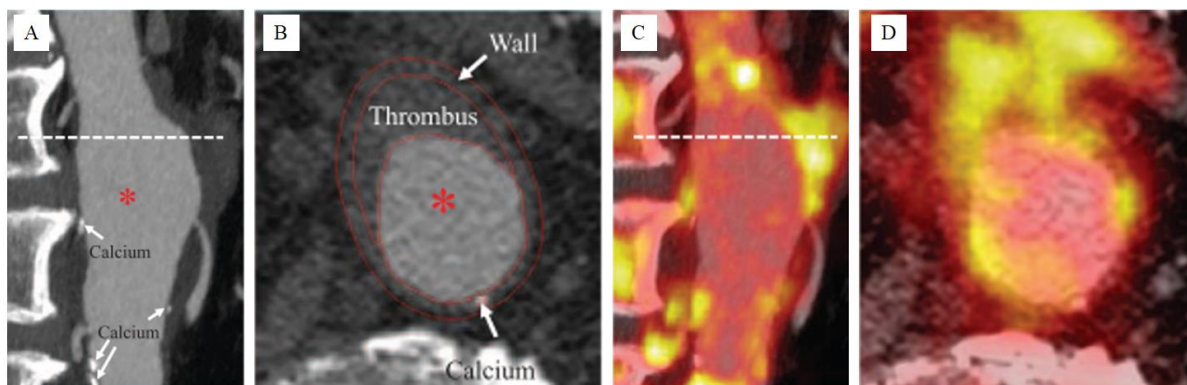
In vivo PET-CT images of an abdominal aortic aneurysm: (A) contrast-enhanced CT, sagittal view; (B) ^{18}F -FDG PET, sagittal view; (C) contrast-enhanced CT, transverse view; (D) ^{18}F -FDG PET, transverse view. (Adapted from Huang *et al.*²⁰⁵, with permission from Wolters Kluwer Health, Inc.)
